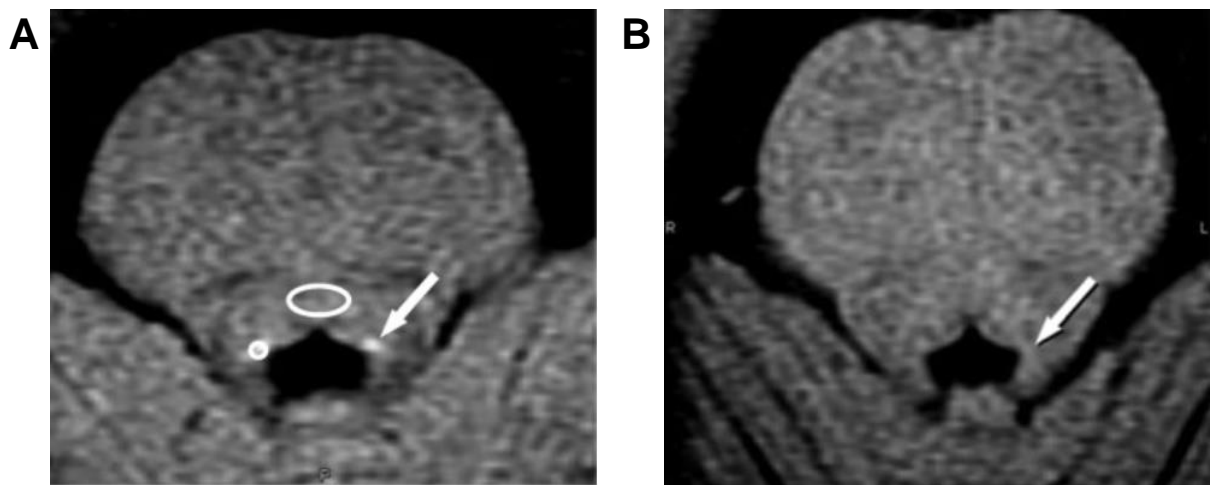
Neuromelanin-sensitive MRI scans.
